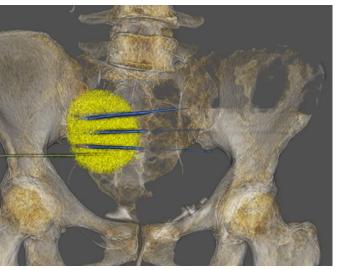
Depicting CT-guided positioning of the cryoprobes with ice ball development.
